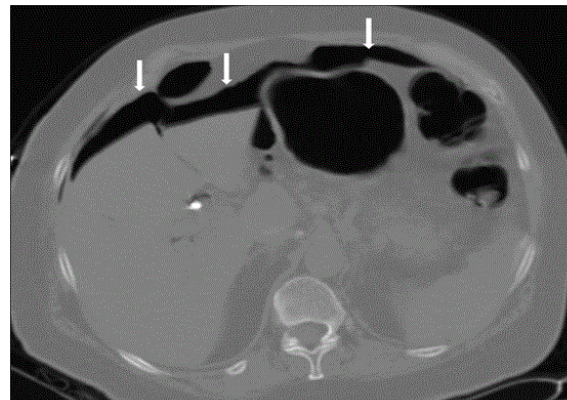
Massive intraperitoneal perforation (type B); a) CT slice at the level of the upper abdomen demonstrated a large quantity of free intraperitoneal air anterior to the liver and stomach (arrows).
